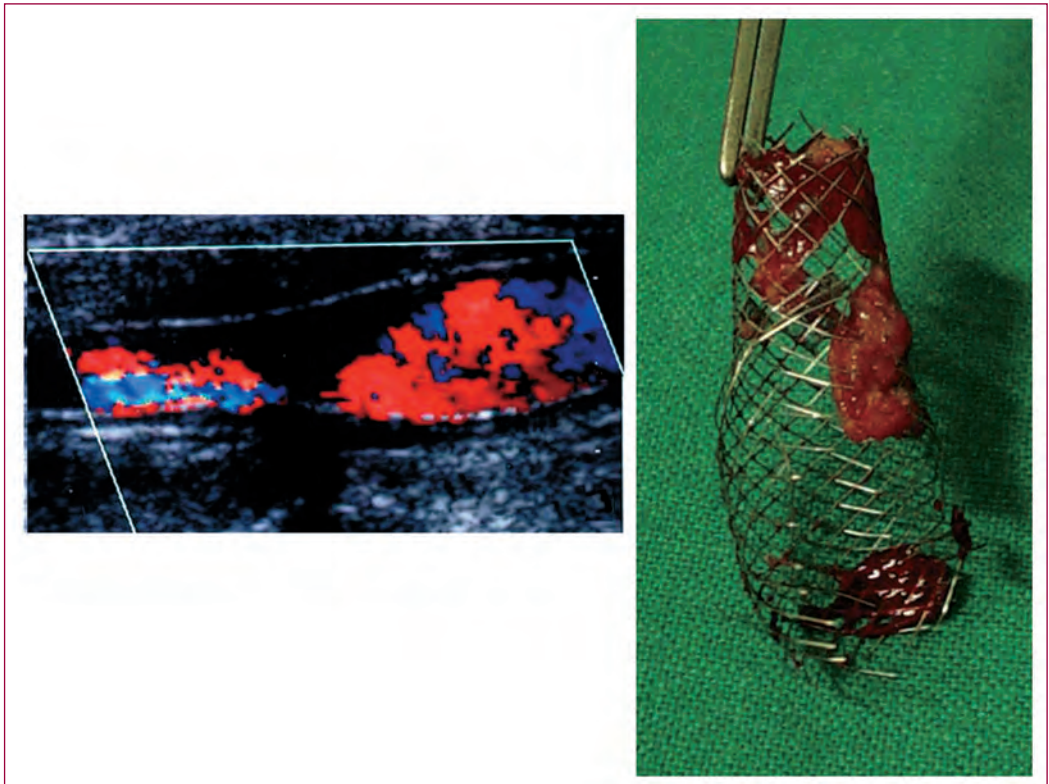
Case of incomplete in-stent thrombosis diagnosed by eco-color-Doppler and its intraoperative finding in which it's evident plaque prolapse through the stent struts.
